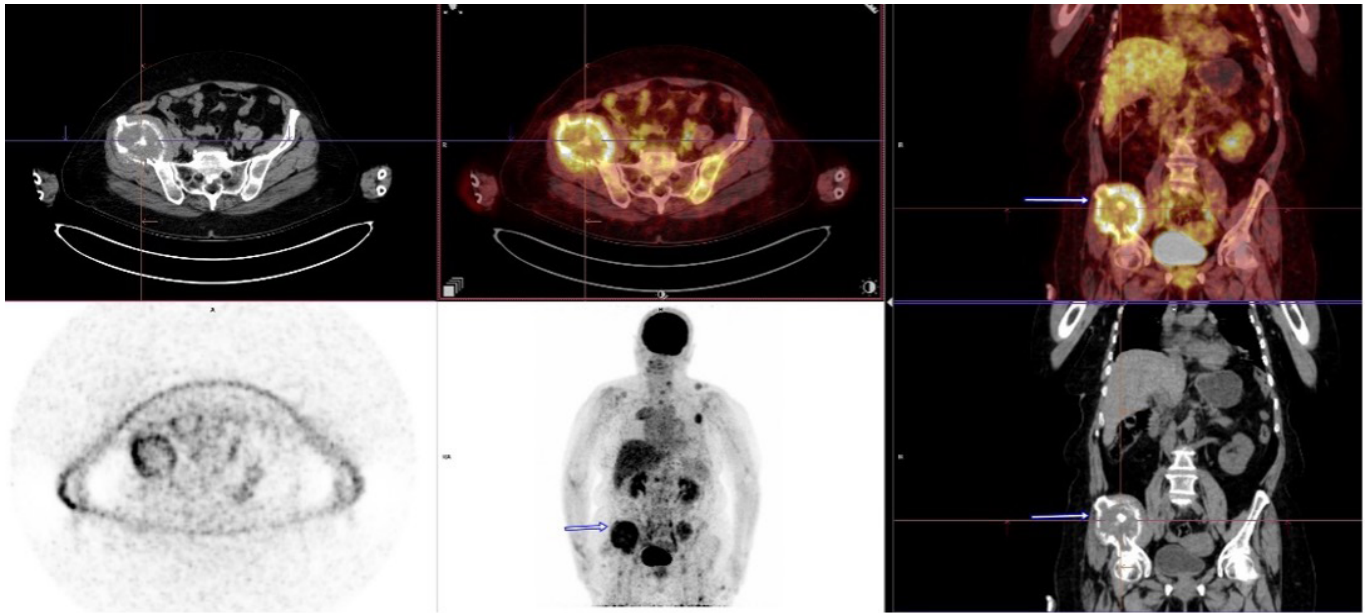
F-18 FDG PET/CT imaging reveals the presence of multiple bone metastases, as indicated by the blue arrows and blue stars.
